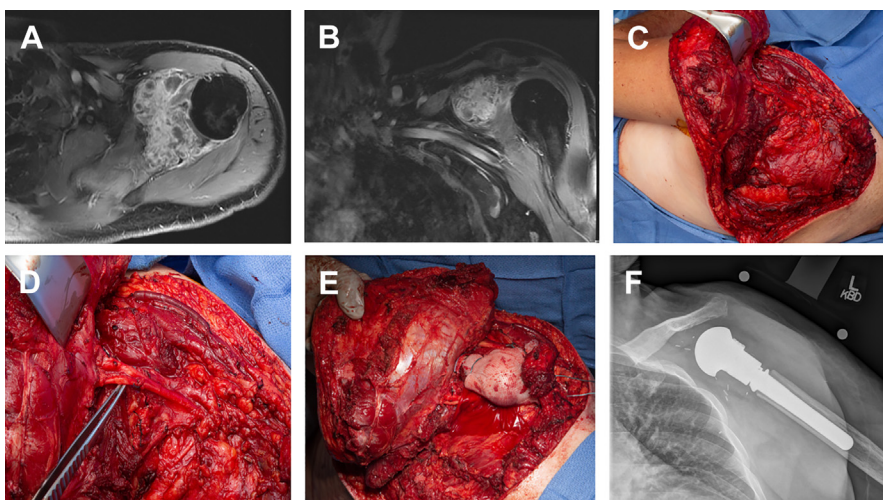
Axial (A) and coronal (B) MRI with contrast showing a chondrosarcoma involving the scapula and glenoid. The patient underwent an extra-articular resection of the proximal humerus and scapula through a utilitarian incision with the posterior limb of the incision (C) shown following scapular resection with preservation of axillary nerve (D). The proximal humerus was reconstructed using an endoprosthesis wrapped in mesh (E), which was suspended from the clavicle (F).
